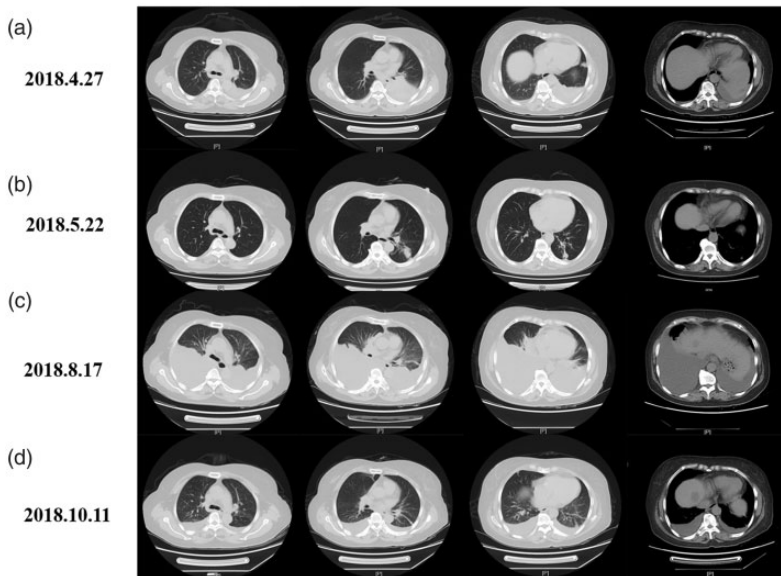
CT findings of the patient before and after therapy. (a) Baseline CT at diagnosis. (b) CT after 3 weeks of crizotinib treatment. (c) CT revealed progress disease after 3 months of reduced-dose crizotinib treatment. (d) CT after 2 months of crizotinib rechallenge. CT, computed tomography.
